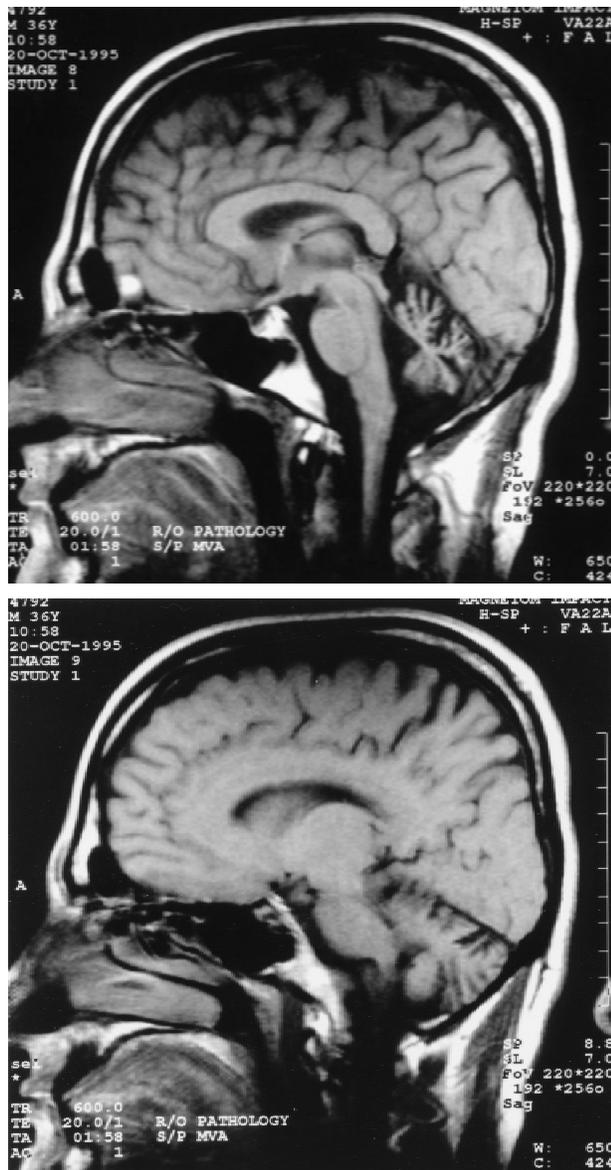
Head magnetic resonance imaging scan. Sagittal, T1-weighted image in the plane of the cerebellar vermis (top) and cerebellar hemisphere (bottom).
